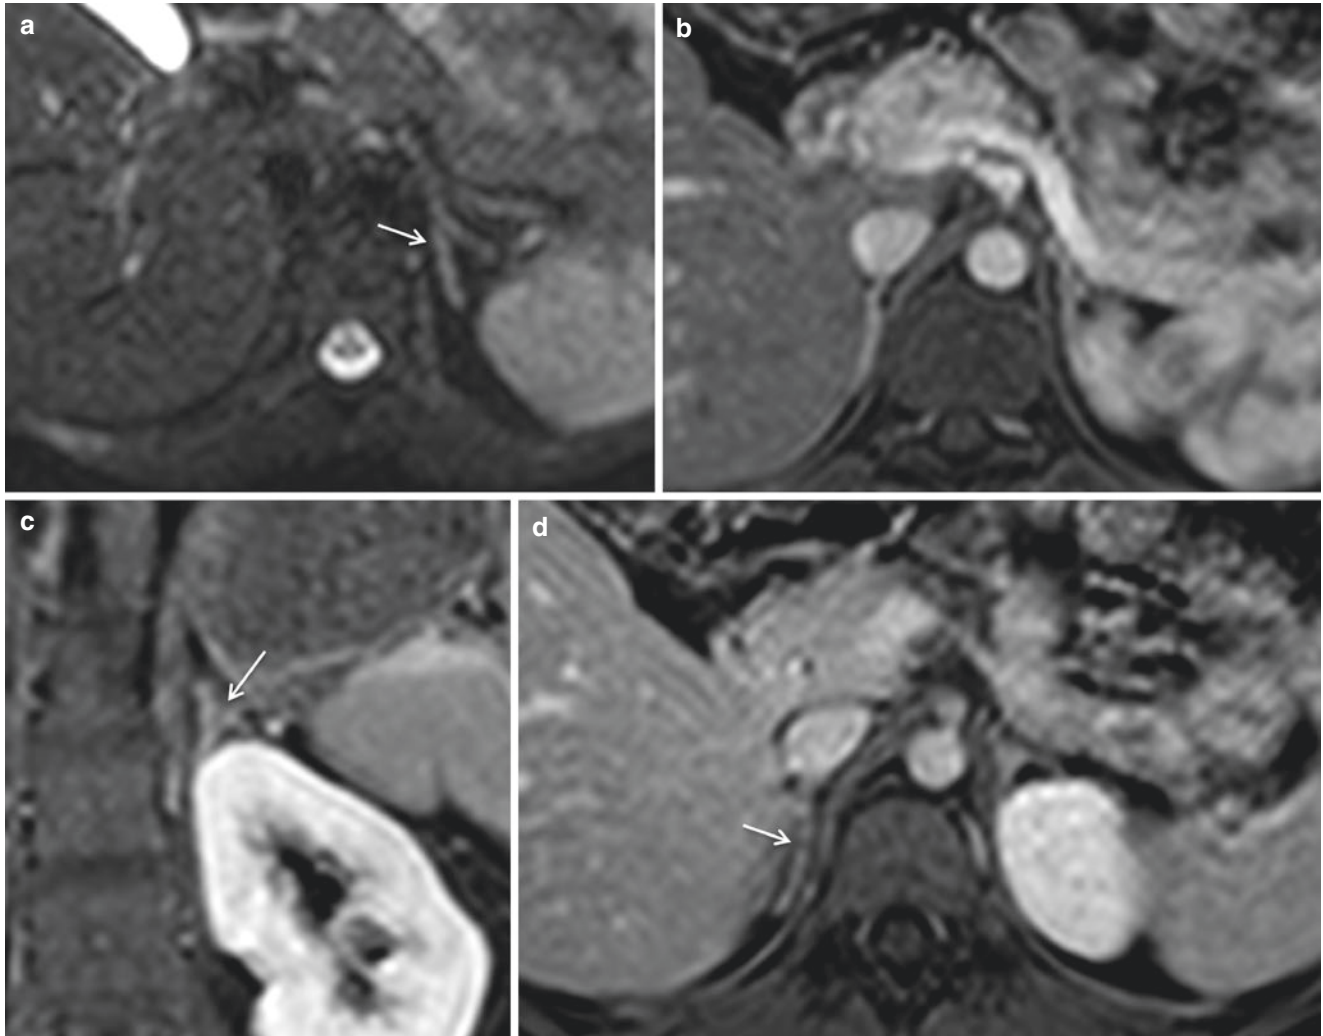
Primary pigmented nodular adrenocortical disease (PPNAD). Axial (a) and post-gadolinium axial (b, d) and coronal (c) T1-weighted MR images. Adrenals showing a “beads-on-a-string” aspect with multiple small nodules (white arrows)
